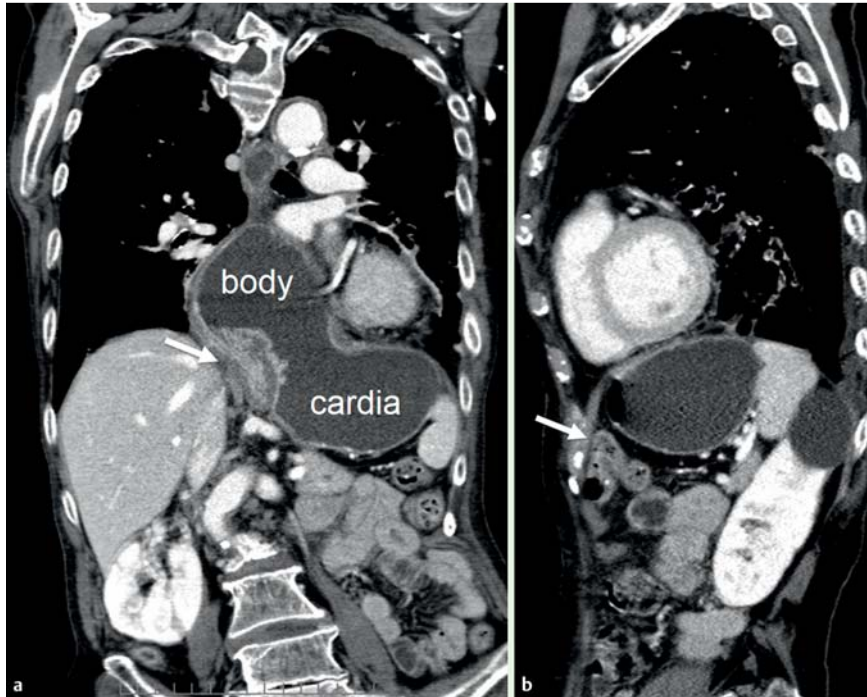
a Abdominal computed tomography (CT) indicated migration of the body of the stomach into the mediastinum (coronal view). The cardia and the body of the stomach are shown. The arrow indicates the antrum of the stomach. b Part of the transverse colon was interposed between the anterior abdominal wall and the stomach (sagittal view). The arrow indicates the transverse colon.
